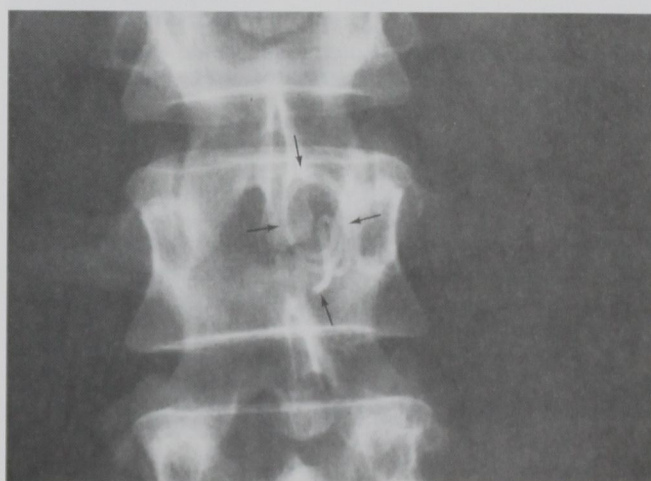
Plain radiograph of the lumbar spine centered on L3 (anteroposterior view) visualizing the residual fragment of sheared catheter (arrows).
